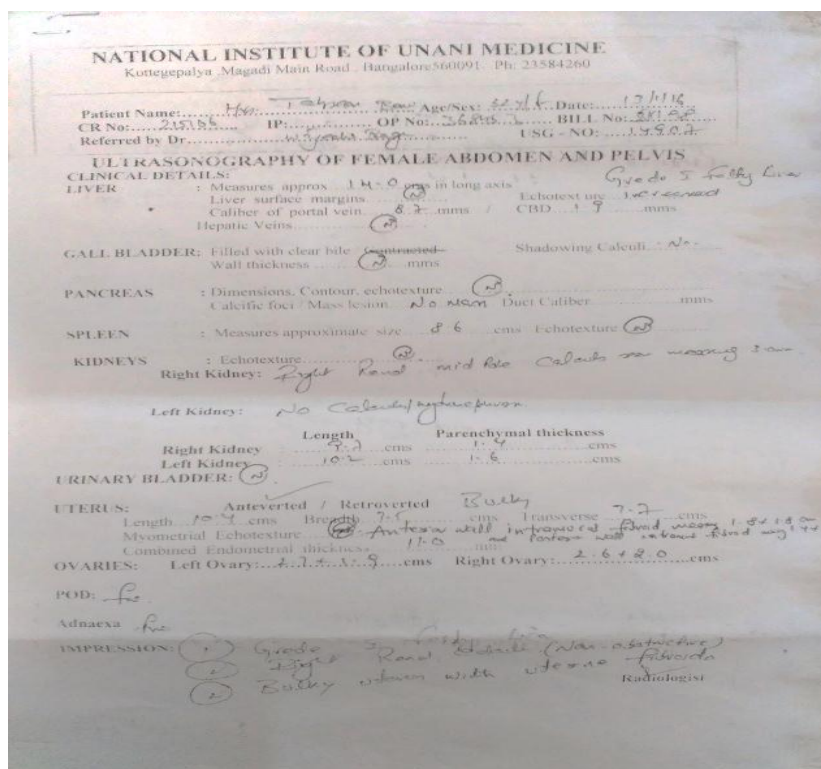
Scanned copies of ultrasound of Pre and post therapy.
